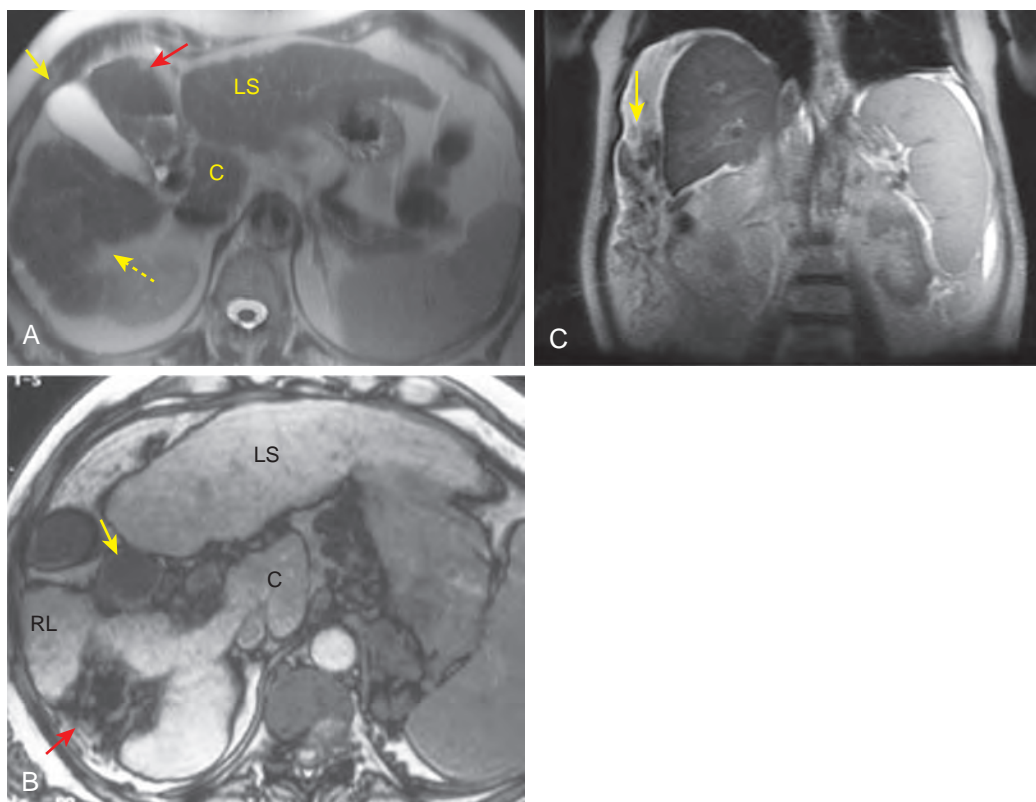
Cirrhosis: MR features. A. T2-weighted MR image demonstrates enlargement of the lateral segment (LS) of the left lobe, atrophy of the medial segment (solid red arrow) of the left lobe, and atrophy of the right lobe with a characteristic notch (broken yellow arrow) on the right posterior surface of the liver. Note that the gallbladder (solid yellow arrow) is in a more superficial and lateral position as a result of these morphologic changes. C, caudate lobe. B. Marked atrophy of the right lobe (RL) of the liver is seen in association with enlargement of the lateral segment (LS) of the left lobe and caudate lobe (C). The gallbladder fossa is widened, and the gallbladder (yellow arrow) and hepatic flexure (red arrow) of the colon are in a superficial location. C. Coronal T2-weighted image shows marked hepatic atrophy associated with ascites and interposition of colon (arrow) between the liver and lateral abdominal wall. Splenomegaly is also present.
